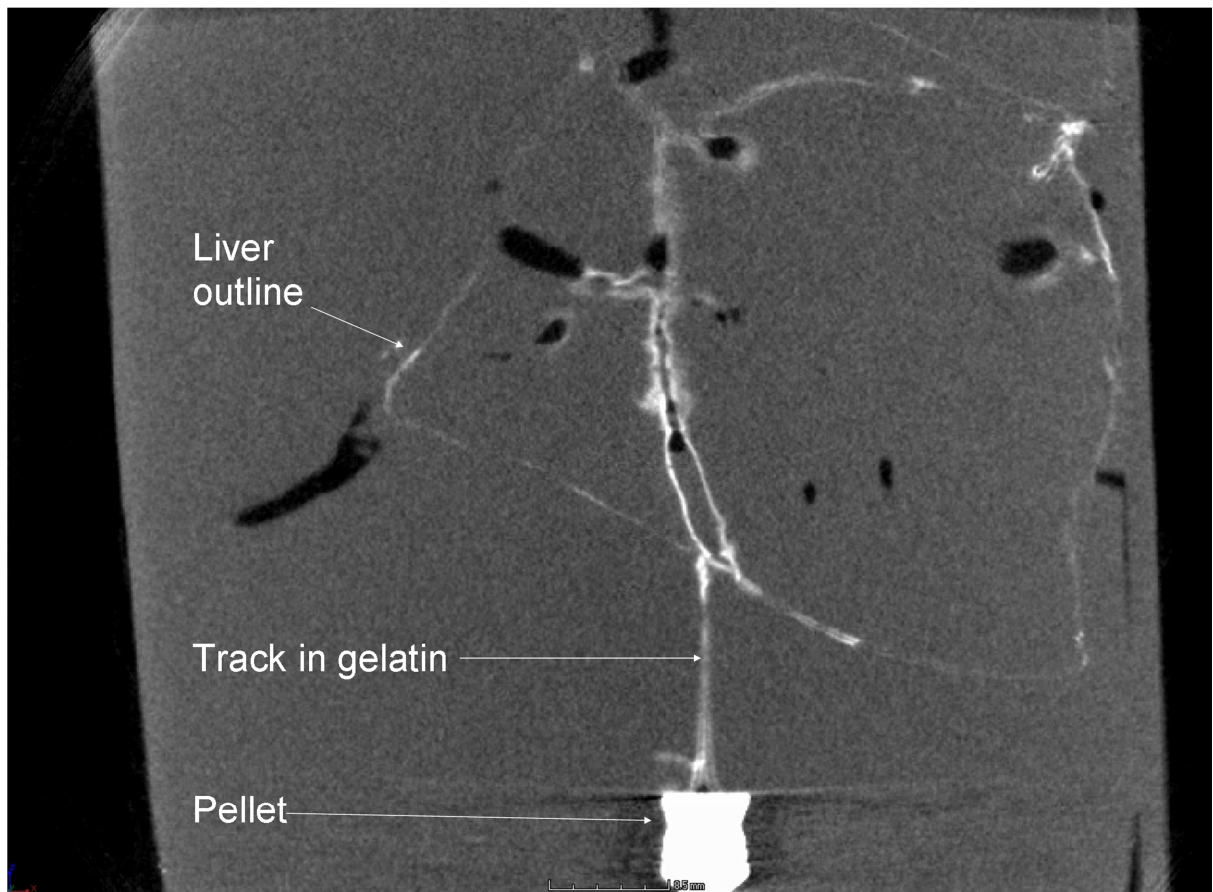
2-dimensional x-ray image through liver
